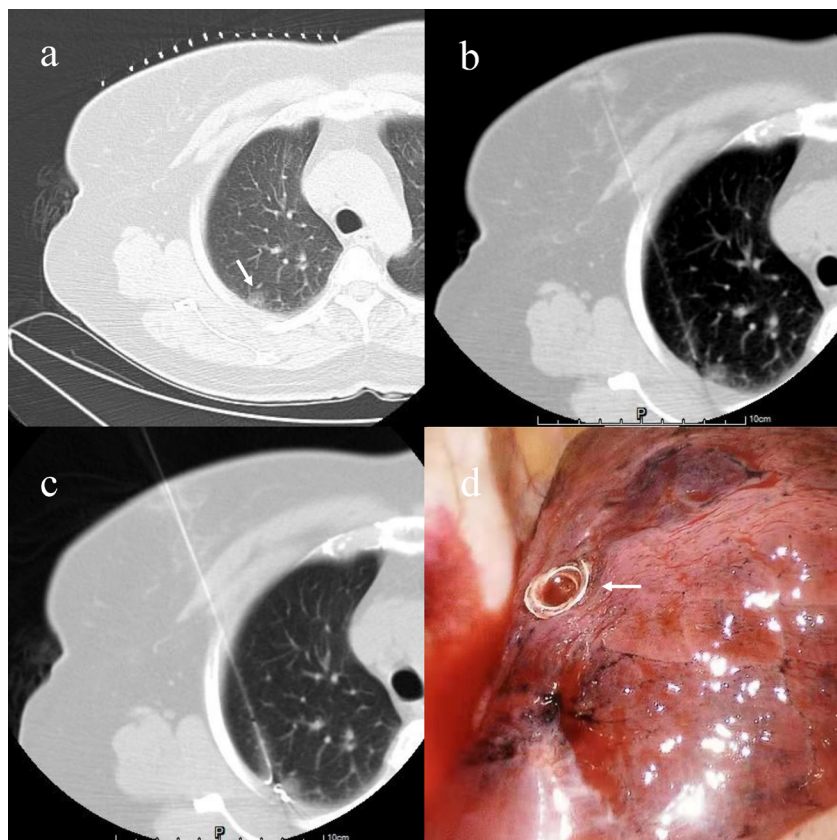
A 49-year-old female with a pulmonary nodule in the right upper lobe. (a) Axial CT image showing lesion (arrowhead) in the right upper lobe. (b) Needle tip was advanced into the normal lung parenchyma adjacent to the lesion and continued to advance to the pleural cavity. (c) The distal end of the coil was first released to the pleural surface, and the tail of the microcoil remained near the nodule. (d) The superficial end of the microcoil (arrowhead) was visualized using a thoracoscope to guide wedge resection. CT, computed tomography.
